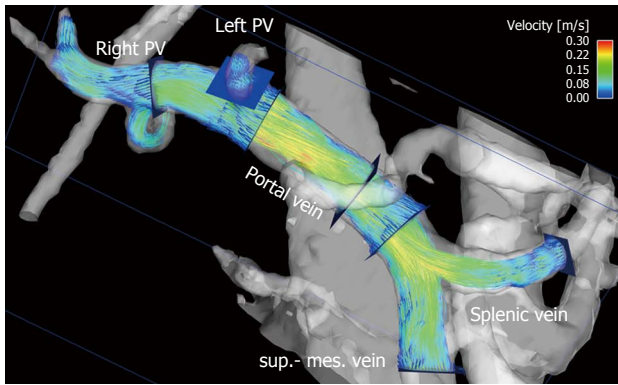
Particle traces visualization of portal venous flow in a healthy volunteer. Blue emitter planes were positioned in the splenic vein and superior mesenteric vein (sup.-mes. vein), portal vein, right (right PV) and left (left PV) intrahepatic portal vein branch. The gray-shaded iso-surface three-dimensional angiogram has been calculated from the 4D flow magnetic resonance imaging data. Color-coded peak velocities in the inflow of the portal vein from the splenic and superior mesenteric veins and the intrahepatic part of the portal vein.
